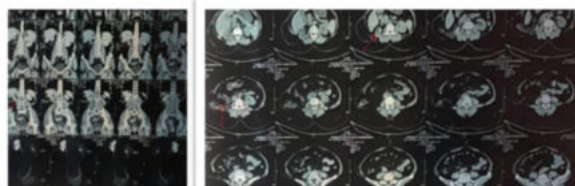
CT IVP Show Large Hernia With Renal Stone (red Arrow)
